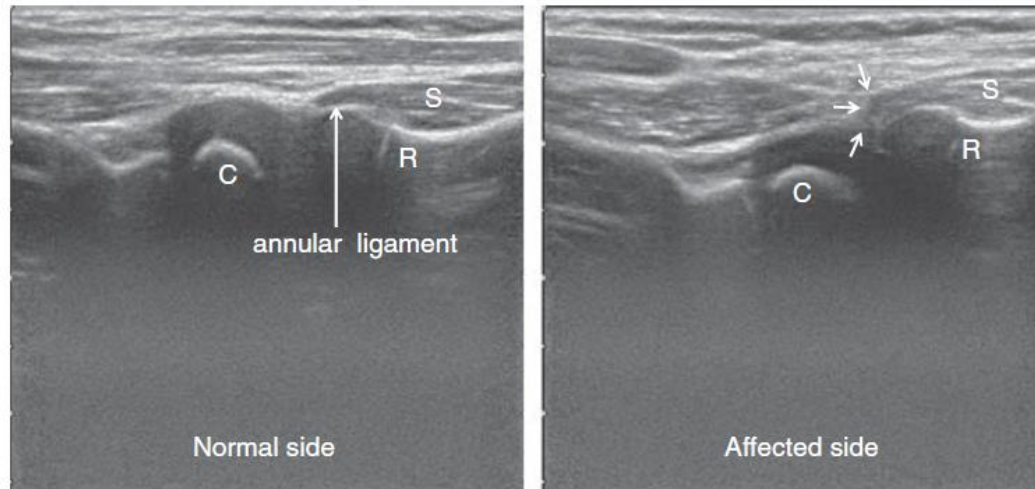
Ultrasonography of the pulled elbow. Anterior long-axis view of the radiohumeral joint. The small arrows indicate J-shaped hypoechoic image. C indicates capitellum; R, radius; S, supinator muscle.
